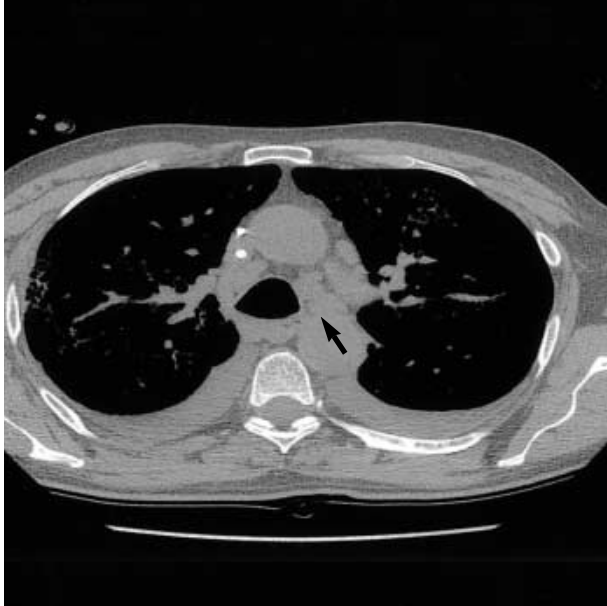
CT scanning shows multiple lymphadenopathies of mediastinal (subcarinal, A-P window, and left lower paratracheal) lymph nodes (arrow).
